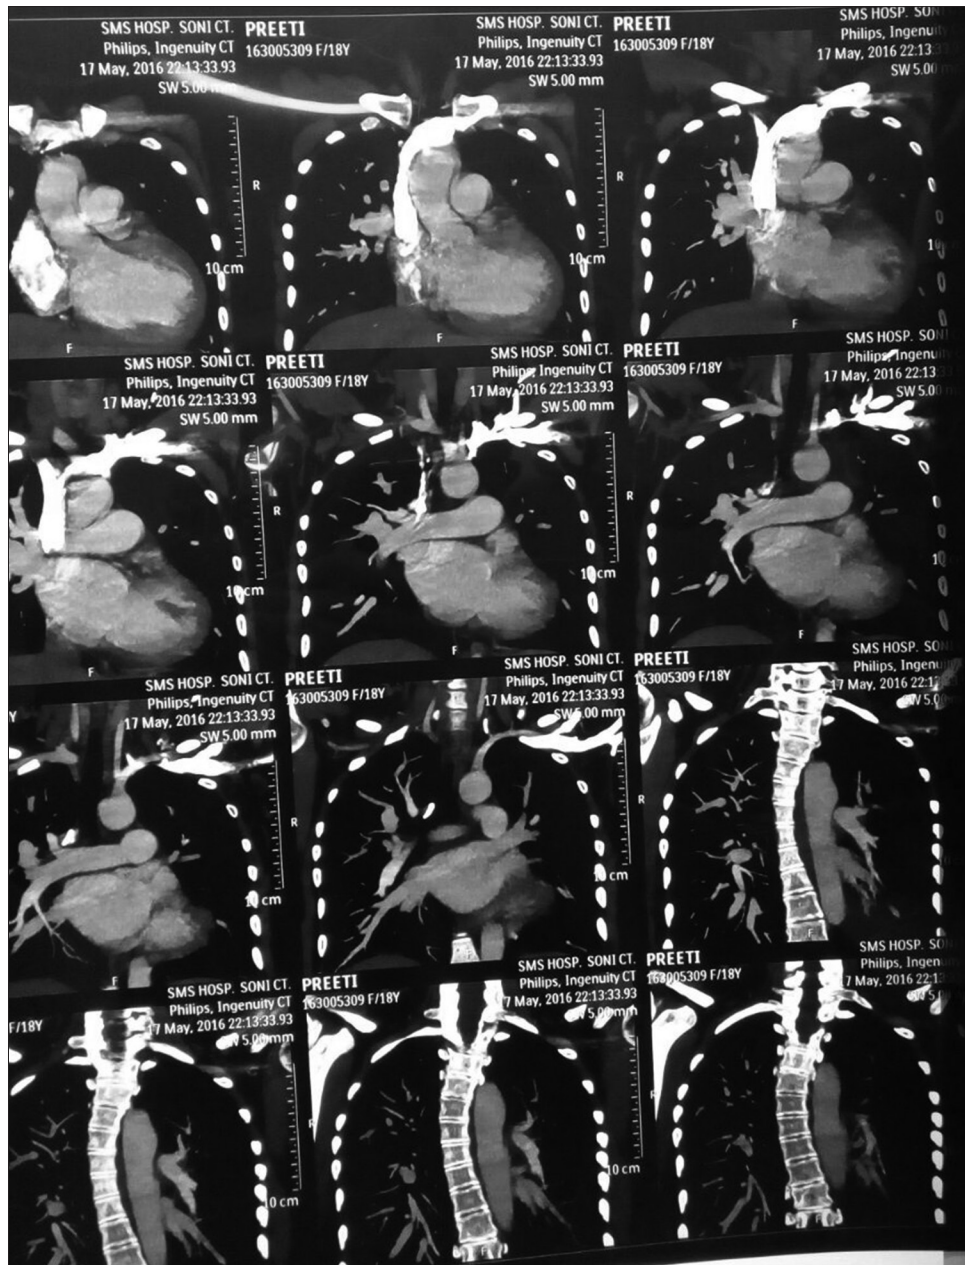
Computed tomography chest angiography showing an abnormal communication between distal pulmonary trunk toward left side and descending aorta with a defect of about 9.7 mm leading to dilatation of pulmonary artery and left pulmonary vein
